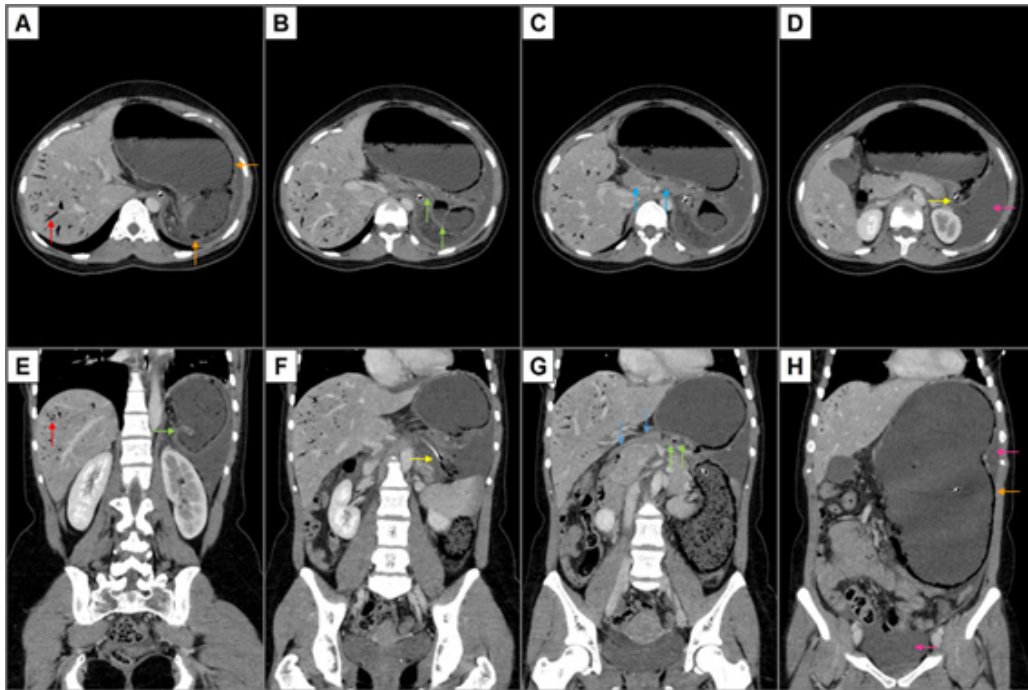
Abdominal and pelvic CT - Axial – from superior to inferior (A–D) – and coronal sections – from posterior to anterior (E–H) – of abdominal and pelvic CT showing significant distension and anomalous position of the stomach with spatial inversion of the positions of the esophagogastric junction (yellow arrows – Figures 1D and 1F) and the antrum/pylorus (green arrows – Figures 1B, 1E and 1G), associated with collapse of the downstream digestive tract segments (blue arrows – Figures 1C and 1G); it also demonstrates gastric parietal pneumatosis (orange arrows – Figures 1A and 1H), portal venous gas (red arrows – Figures 1A and 1E) and free intra-abdominal fluid (pink arrows – Figures 1D and 1H). The combination of these findings suggested the diagnosis of mesenteroaxial gastric volvulus complicated by gastric ischemia.
